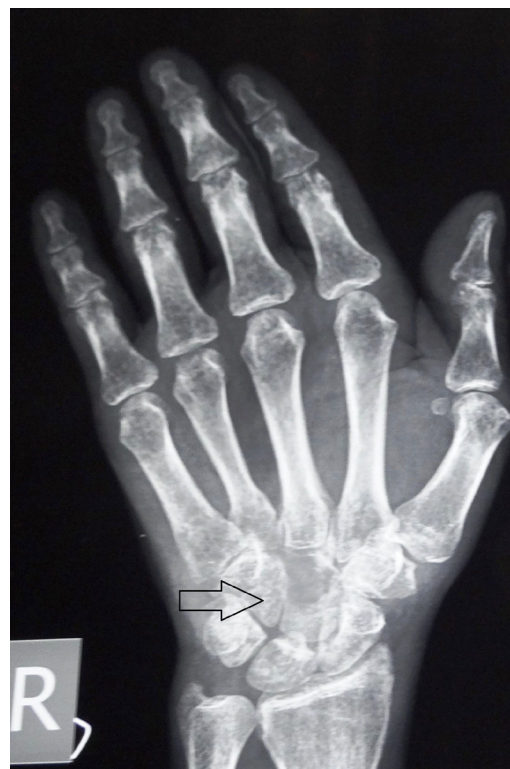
Radiograph of the right hand revealing a lytic lesion in capitate bone.
